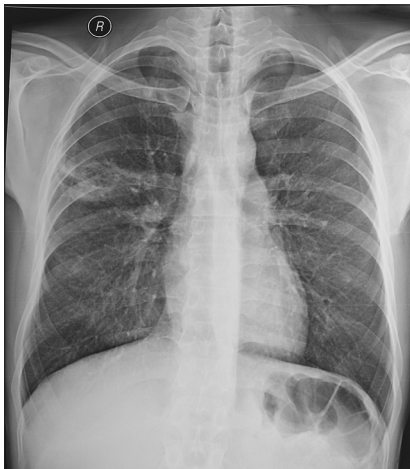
X-ray showing clearing of right cavitory lesion on treatment
